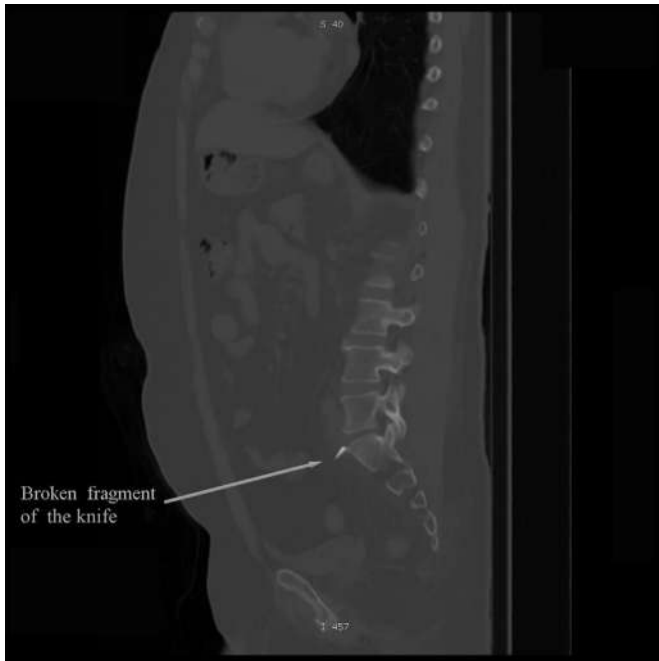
X-ray showing broken piece of knife.
